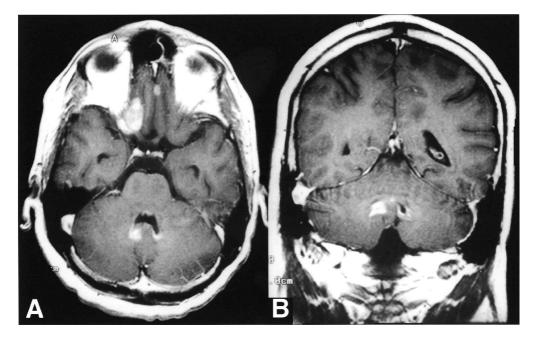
Axial (A) and coronal (B) gadolinium-enhanced T1-weighted spin-echo MRIs obtained due to intractable vomiting (a few months after surgical resection of GBM) demonstrating enhancement of the metastatic deposits around the fourth ventricle.
